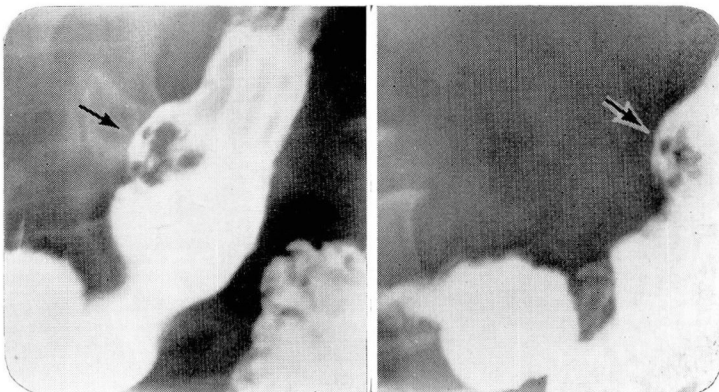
Roentgenograms of the stomach after ingestion of barium, showing large gastric varices on the lesser curvature.
